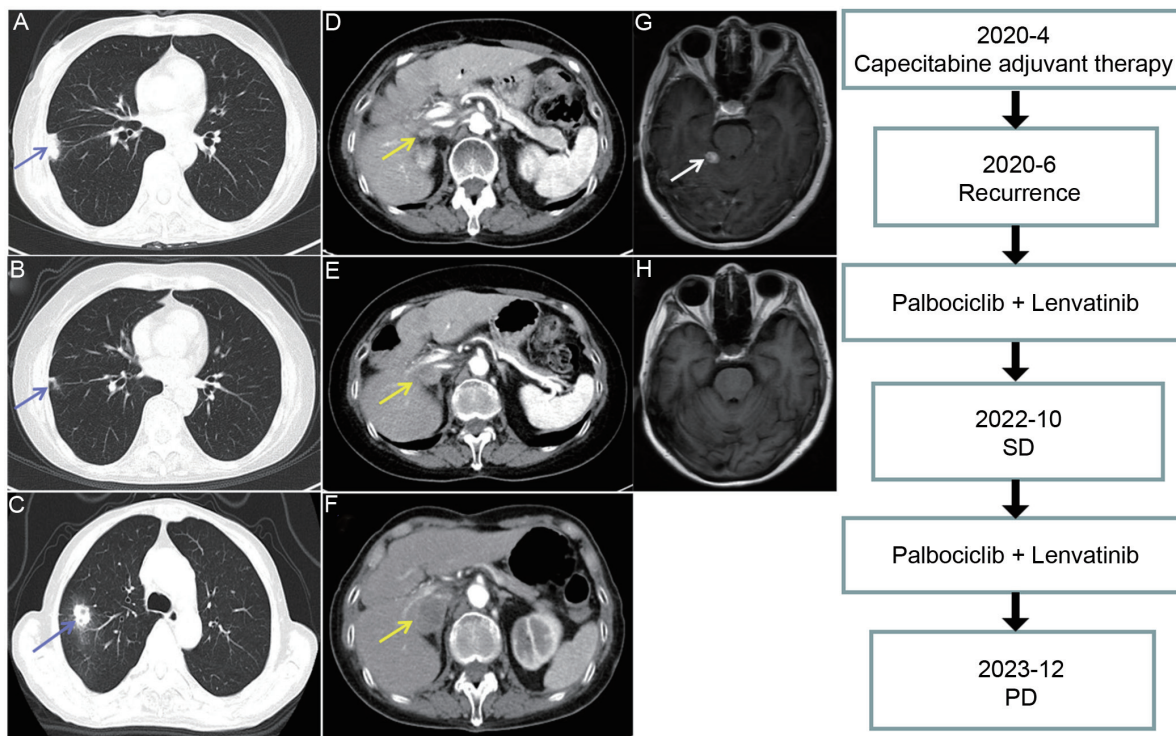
Images of the patient during treatment. (A) CT showed tumor recurrence in the right lung. (B) CT showed that the lung metastasis had significantly shrunk. (C) CT showed a new metastasis appeared in the right lung. (D) CT showed tumor recurrence in the right adrenal gland. (E) CT showed the right adrenal gland metastasis was slightly larger than before. (F) CT showed the right adrenal gland metastasis was more than 20% larger than before. (G) MRI showed an intracranial metastasis. (H) MRI showed the intracranial metastasis had disappeared. Blue arrows point to lung lesions; Yellow arrows point to adrenal lesions; White arrows point to intracranial lesions. CT, computed tomography; SD, Stable disease; PD, Progressive disease; MRI, magnetic resonance imaging.
